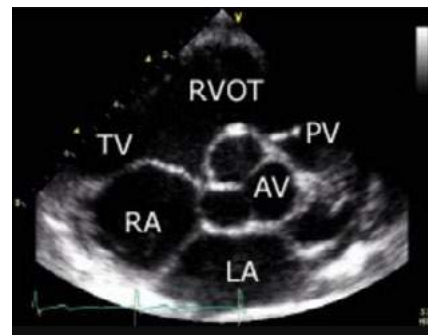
2-D echocardiography in the parasternal short axis view at the base of the heart. AV = aortic valve, LA = left atrium, RA = right atrium, TV = tricuspid valve, RVOT = right ventricular outflow tract, PV = pulmonary valve
